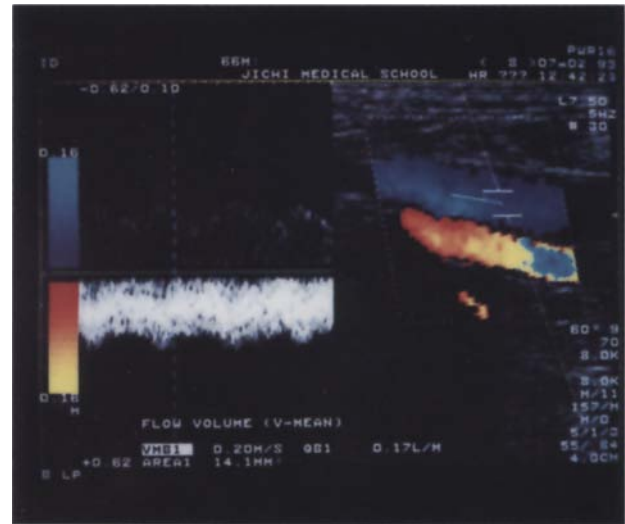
Ultrasonography of the common femoral vein. Figure on the left side shows blood velocity in the femoral vein using color-doppler ultrasound; the right side shows longitudinal section of the femoral vein using B-mode ultrasonography.
